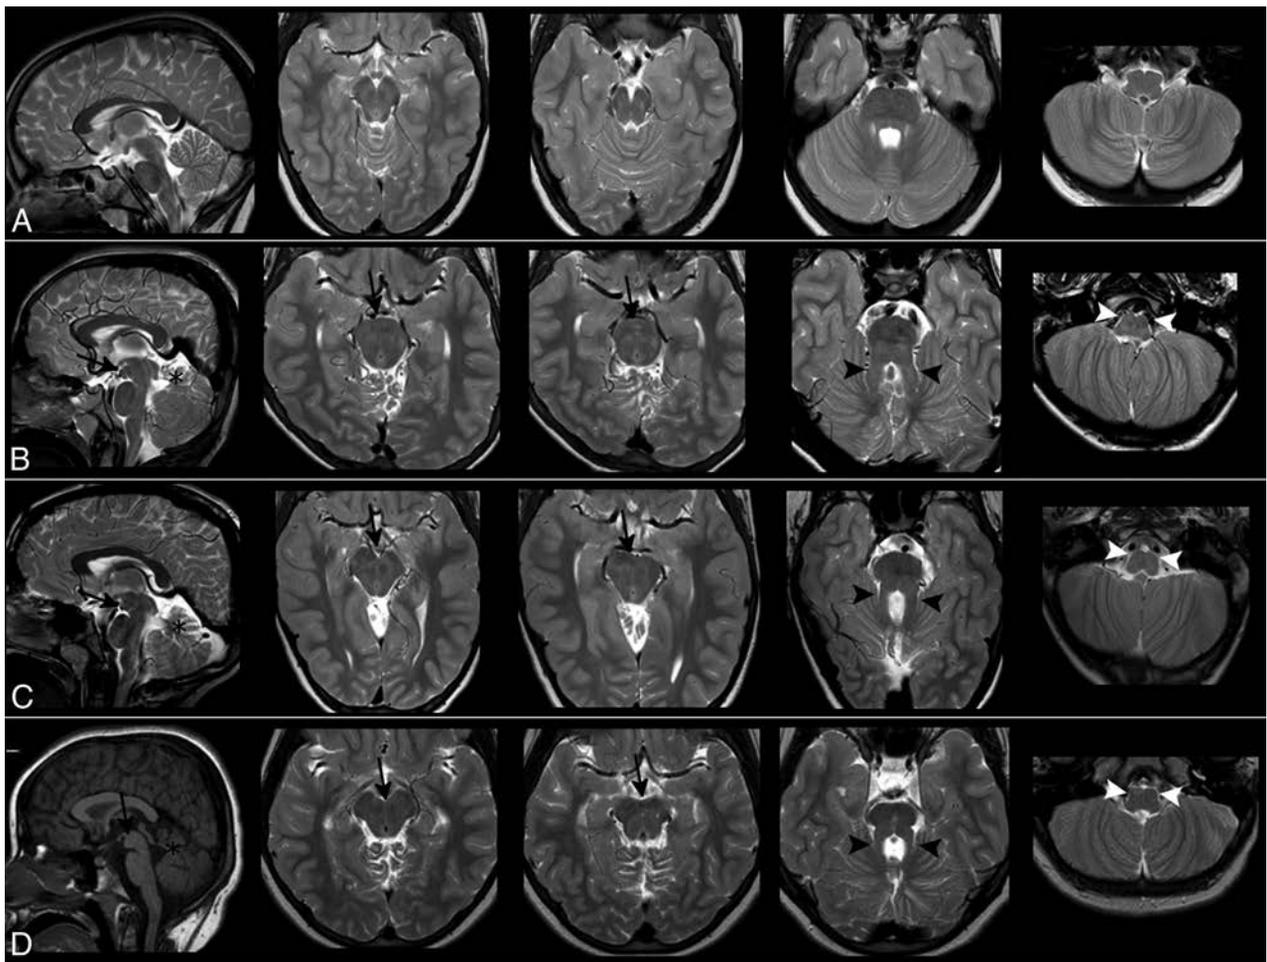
Morphologic findings. Images show T1- and T2-weighted sagittal and axial sections of a healthy subject (row A), patient 1 (row B), patient 2 (row C), and patient 3 (row D). In the 3 patients, the mesencephalon shows an anterior bulging (black arrows) that fills the interpeduncular cistern, visible both on sagittal and axial sections. The signal intensity of the abnormal mass is like that of white matter. Patients also share the classic features of mesial temporal sclerosis: cerebellar hypodysplasia (black asterisks), a thickened and horizontal SCP (black arrowheads), and hypoplasia of the medullary pyramids and inferior olivary nuclei (white arrowheads).
